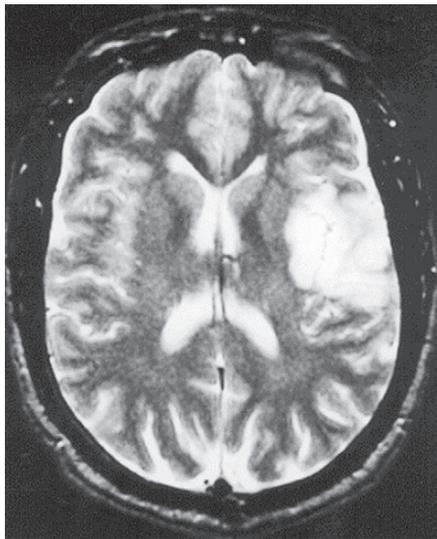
Magnetic resonance imaging showing early ischemic changes obtained 6 hours after the onset of right-sided weakness in a patient with an occluded left internal carotid artery. (Courtesy of Gregory W. Albers, Stanford University, Stanford, Calif.)
